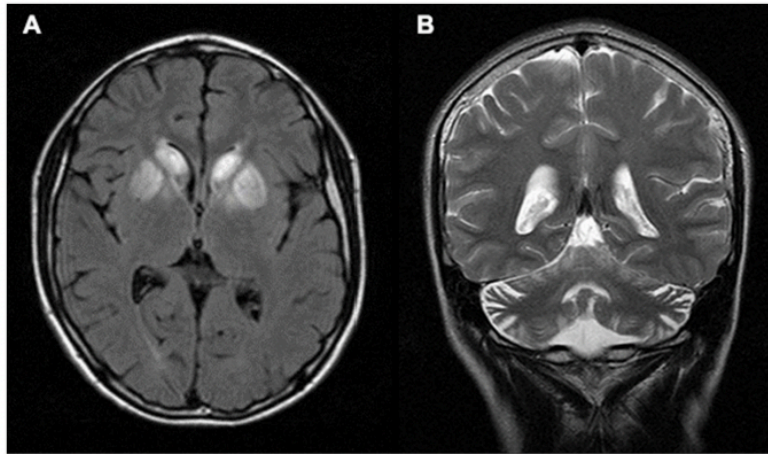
Brain MRI. (A) Axial FLAIR image of the patient showing hyper-signal changes bilaterally in caudate bodies and lentiform nuclei. (B) Coronal T₂ image showing cerebellar atrophy.
